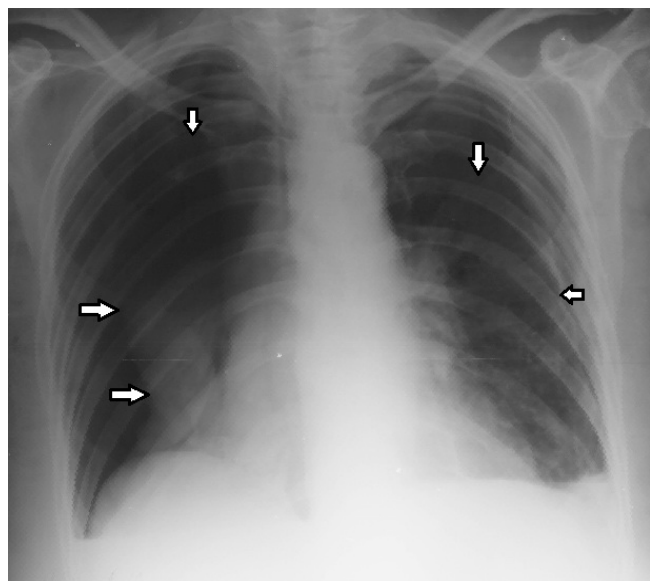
PA X-ray demonstrated a pneumothorax in the right and left hemithorax (see arrows)
